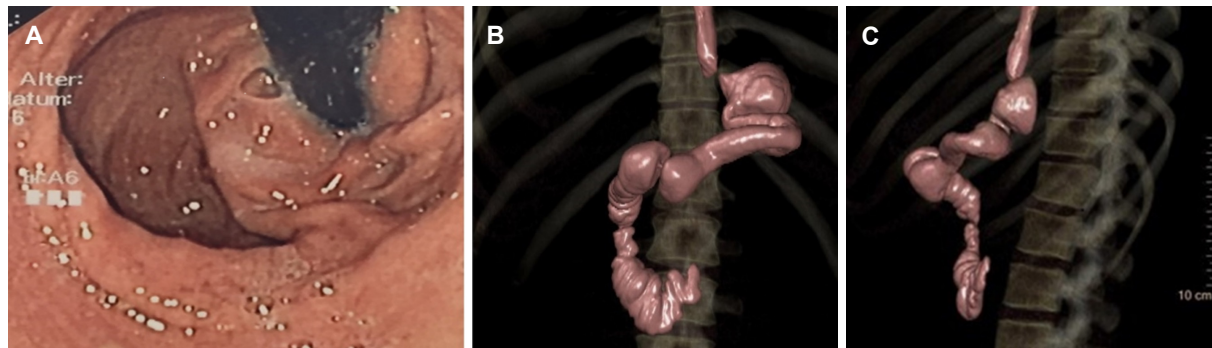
Patient after sleeve gastrectomy with remnant part of fundus, which is herniated to the mediastinum. The sleeve itself is twisted: Endoscopic and 3D-CT view
